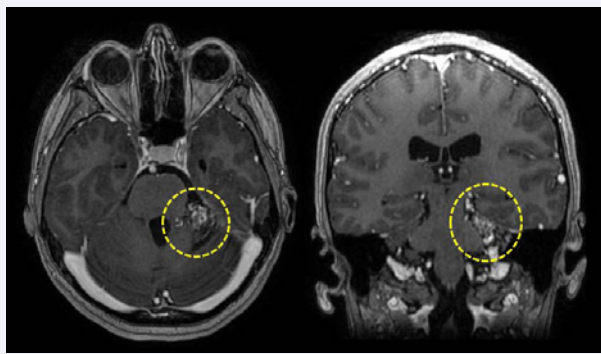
T1 MRI with contrast show a vascular lesion in upper left cerebellar peduncle (yellow circle).
